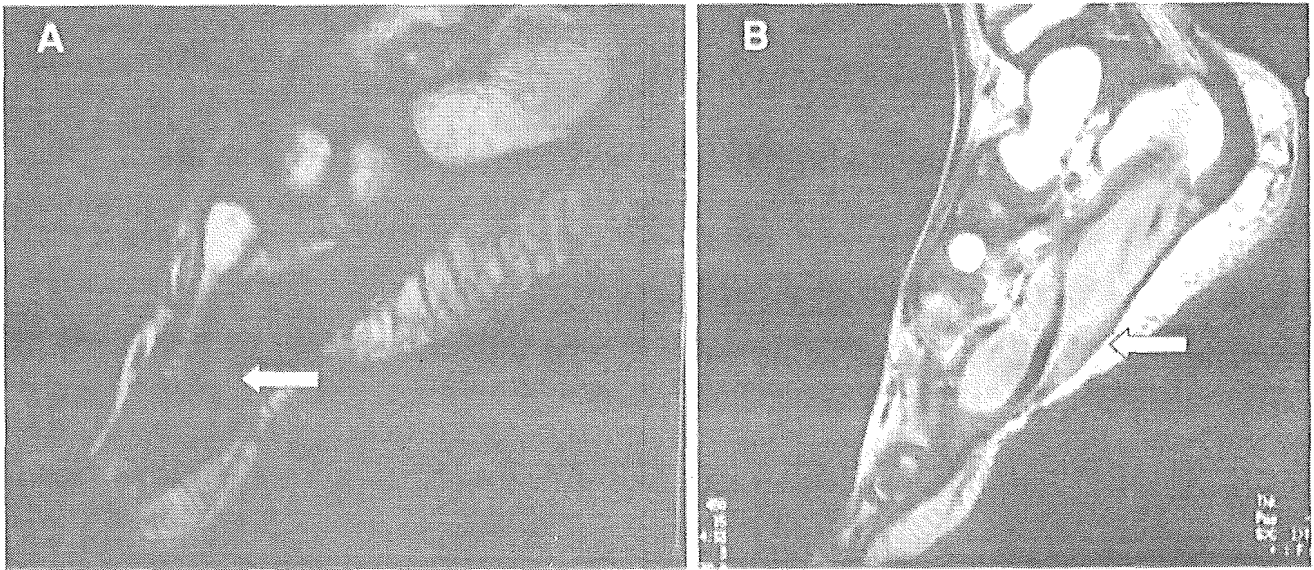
MRI findings after AO-PDT in Case 1. A: Sagittal T2-weighted image at 12 months after AO-PDT showing no recurrence of tumor (arrow). B: Sagittal T1-weighted image after enhancement with gadolinium demonstrates a recurrent tumor (arrow).
